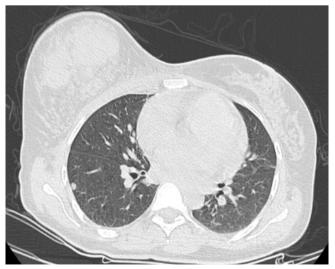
Axial computed tomography scan demonstrating multiple pulmonary metastases
